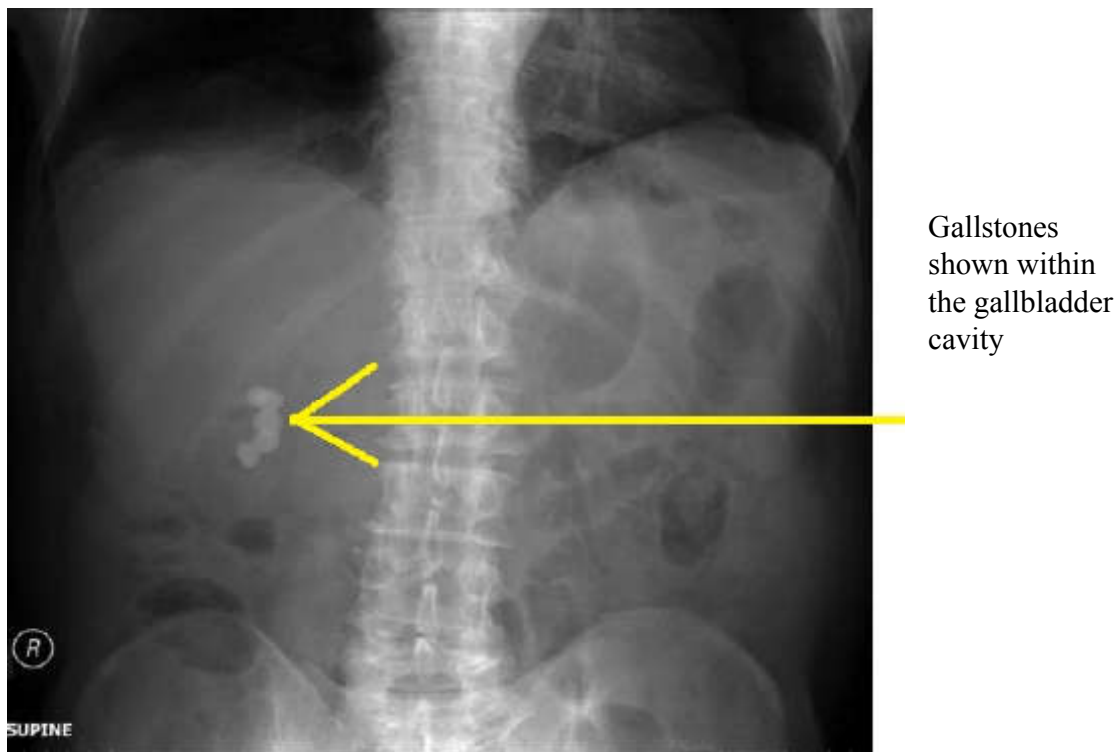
Abdominal radiography (https://www.wikidoc.org/index.php/Gallstone_disease_x_ray)
